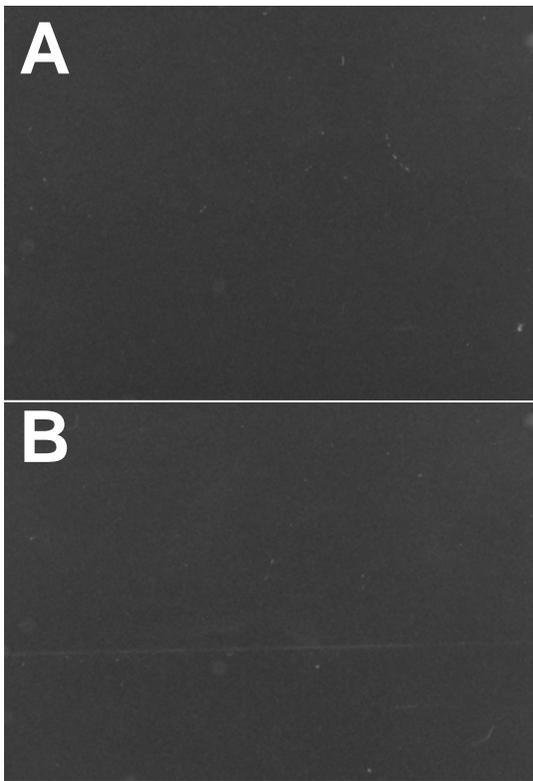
Representative x-ray images of brain sections treated with 1 μM N/OFQ plus ^{125}I -[^{14}Tyr]-N/OFQ. Sections treated with 1 μM N/OFQ plus ^{125}I -[^{14}Tyr]-N/OFQ did not display any specific signal, and background levels were comparable to those sections treated with only ^{125}I -[^{14}Tyr]-N/OFQ.
